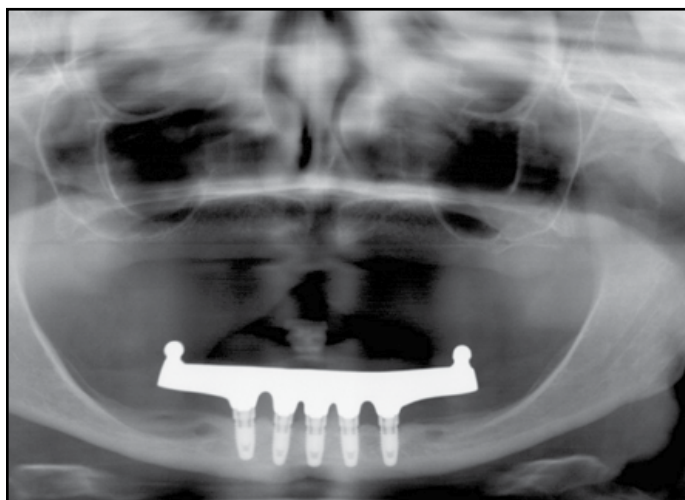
Panoramic x-ray capturing mandible with an implant-supported milled bar.
